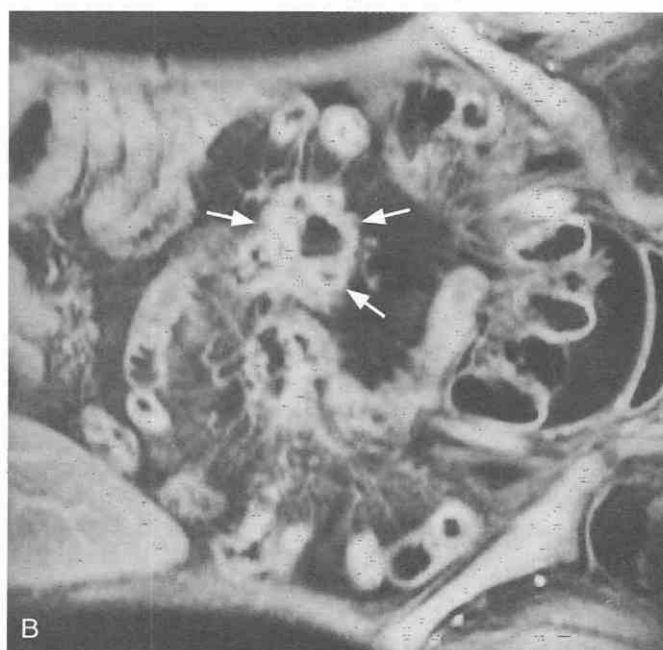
Crohn's disease. CT shows diffuse bowel wall thickening (asterisks) of the small intestine with a skipped segment. Minimal lymphadenopathy is seen in the mesentery.
